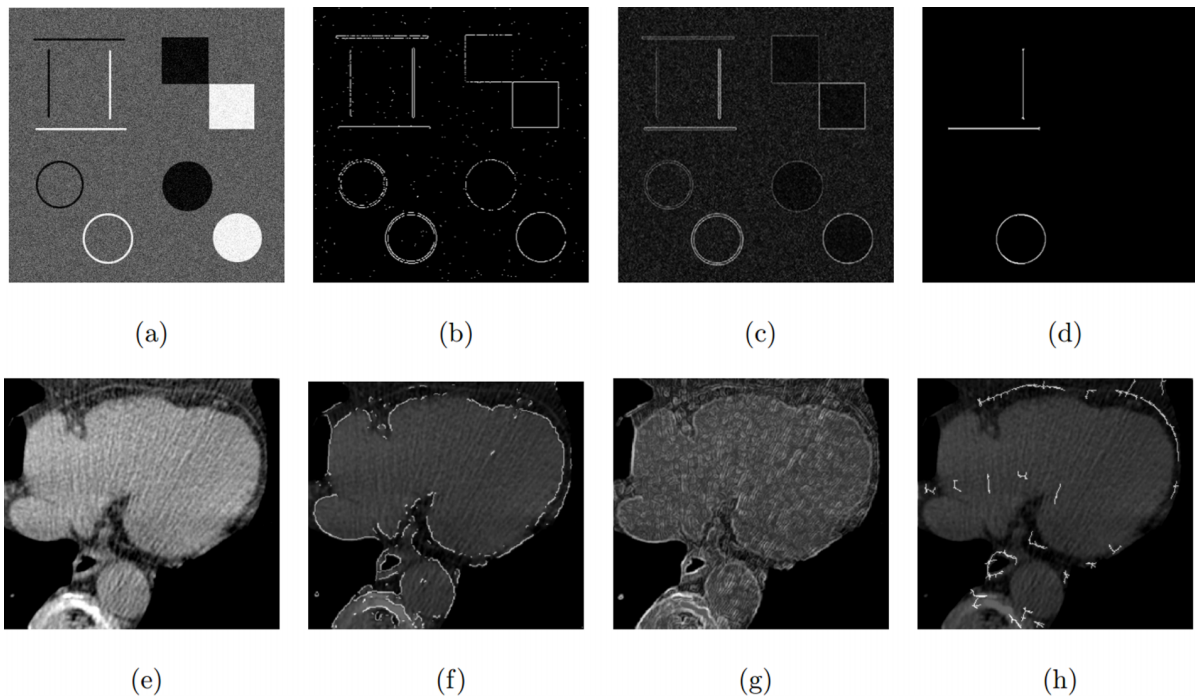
Comparison of edge/line detection methods: [(a) and (e)] input synthetic and cardiac CT images, [(b) and (f)] Canny edge detection results: respond to edges between any objects with different intensities. [(c) and (g)] Gradient vector values: respond to intensity change in any directions, especially the boundary of the heart. [(d) and (h)] Our pericardium detection result: respond mostly to the pericardial sac.
